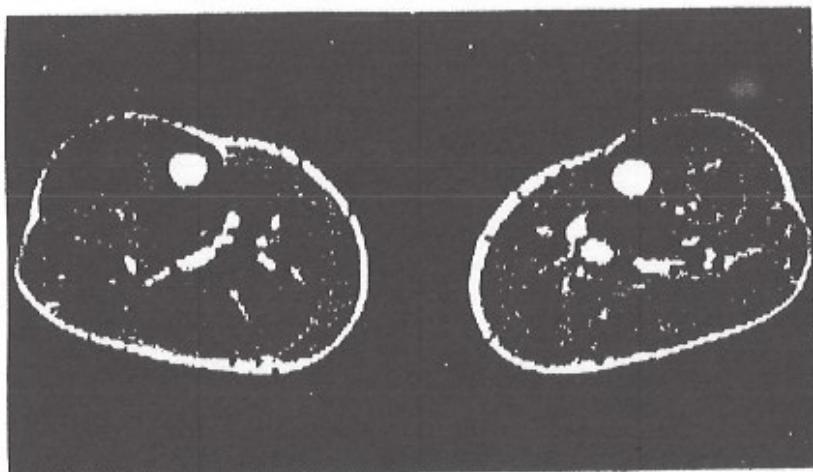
Case 2: MRI of the lower legs (TR 1600 msec/TE 30 msec; before therapy). Only slightly increased signal intensities in the medial head of the right gastrocnemius muscle (left side of the figure).
